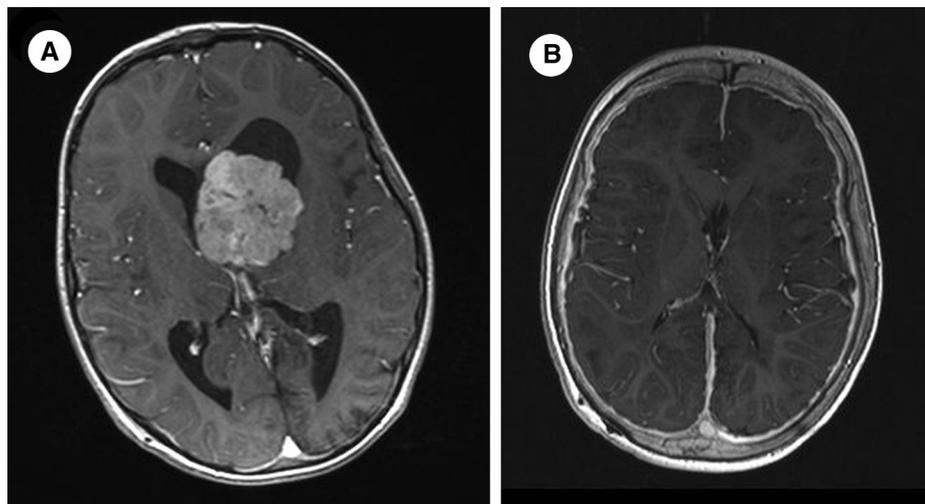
Brain magnetic resonance image showing a large subependymal giant cell astrocytoma located near the foramen of Monro and causing hydrocephalus in a tuberous sclerosis complex patient (A). Postsurgery brain magnetic resonance image of the same patient showing complete resection of the tumor (B).
